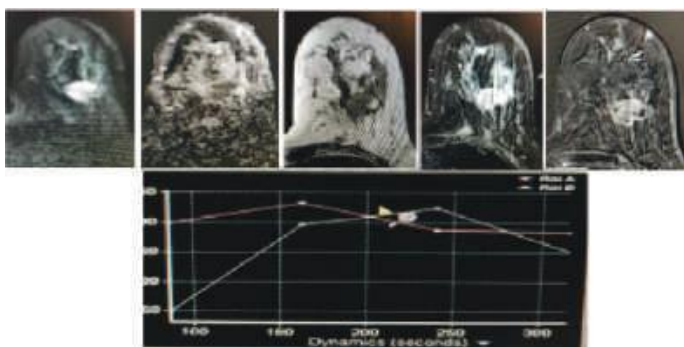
Dynamic Breast MRI – DWI, T2 and Fat Sat T2 and Dynamic Contrast Scan with Type-3 Curve suggesting Malignant Lesion
